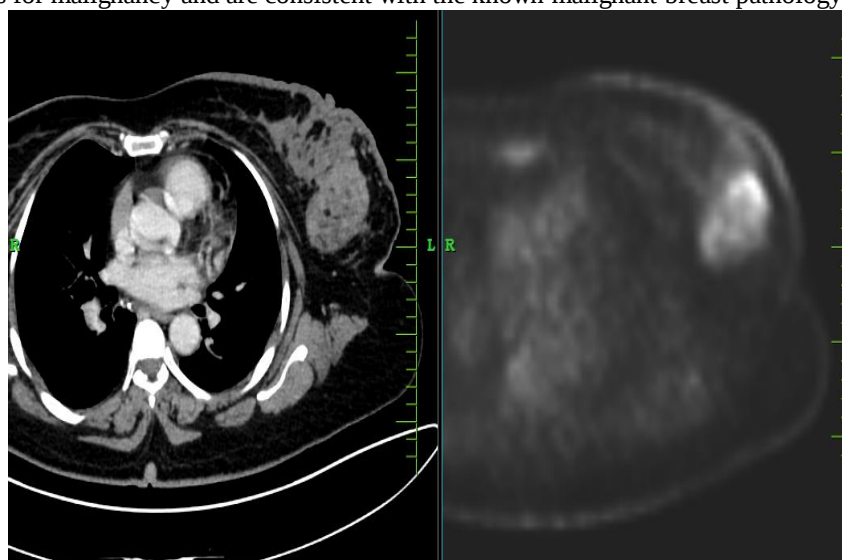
18F-FDG PET/CT demonstrating metabolically active left breast lesions. Increased FDG uptake is noted within heterogeneously enhancing soft-tissue-density lesions involving the upper outer and lower outer quadrants of the left breast. The largest lesion measures approximately 2.1×1.2 cm, with a SUVmax of 20.6. The presence of metabolically active
